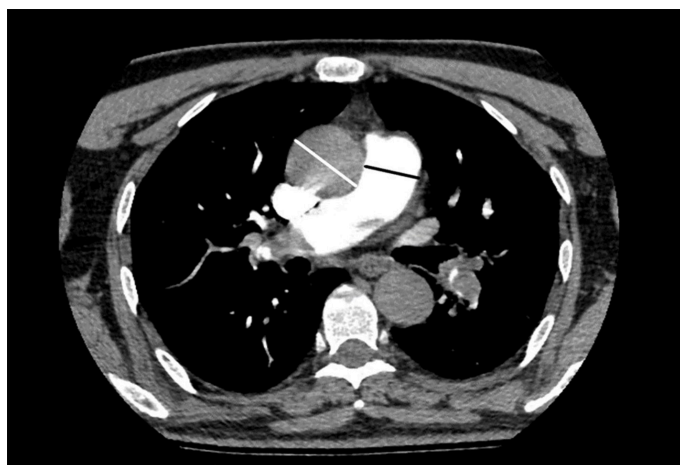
Computed tomography-pulmonary angiography axial section shows ascending aorta diameter (white line) and pulmonary artery diameter (black line) measurements in the mediastinal window. Embolism is observed in the right pulmonary artery and left lobar arteries
